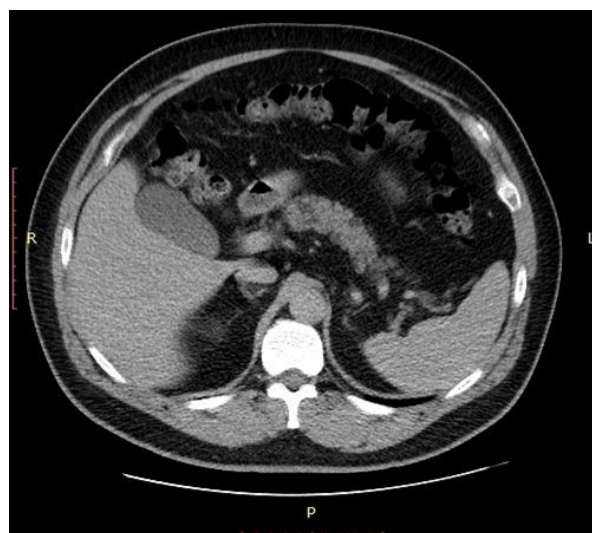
Computed tomography of the abdomen and pelvis with contrast showing acute interstitial pancreatitis involving the uncinate process of the pancreas.
